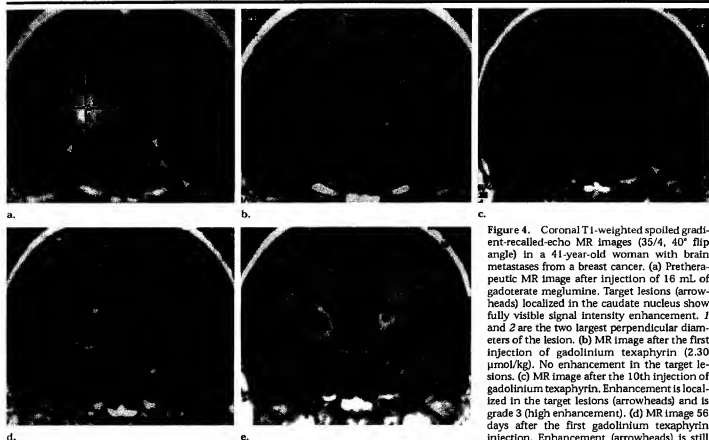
Coronal T1-weighted spoiled gradient-recalled-echo MR images (35/4, 40° flip angle) in a 41-year-old woman with brain metastases from a breast cancer. (a) Pretherapeutic MR image after injection of 16 mL of gadoterate meglumine. Target lesions (arrowheads) localized in the caudate nucleus show fully visible signal intensity enhancement. 1 and 2 are the two largest perpendicular diameters of the lesion. (b) MR image after the first injection of gadolinium texaphyrin (2.30 $\mu\text{mol/kg}$). No enhancement in the target lesions. (c) MR image after the 10th injection of gadolinium texaphyrin. Enhancement is localized in the target lesions (arrowheads) and is grade 3 (high enhancement). (d) MR image 56 days after the first gadolinium texaphyrin injection. Enhancement (arrowheads) is still visible and is grade 3. Tumor decreased to 68% of initial size. (e) MR image 16 weeks after the first gadolinium texaphyrin injection. Enhancement (arrowheads) is still visible and is grade 1 (moderate enhancement).
